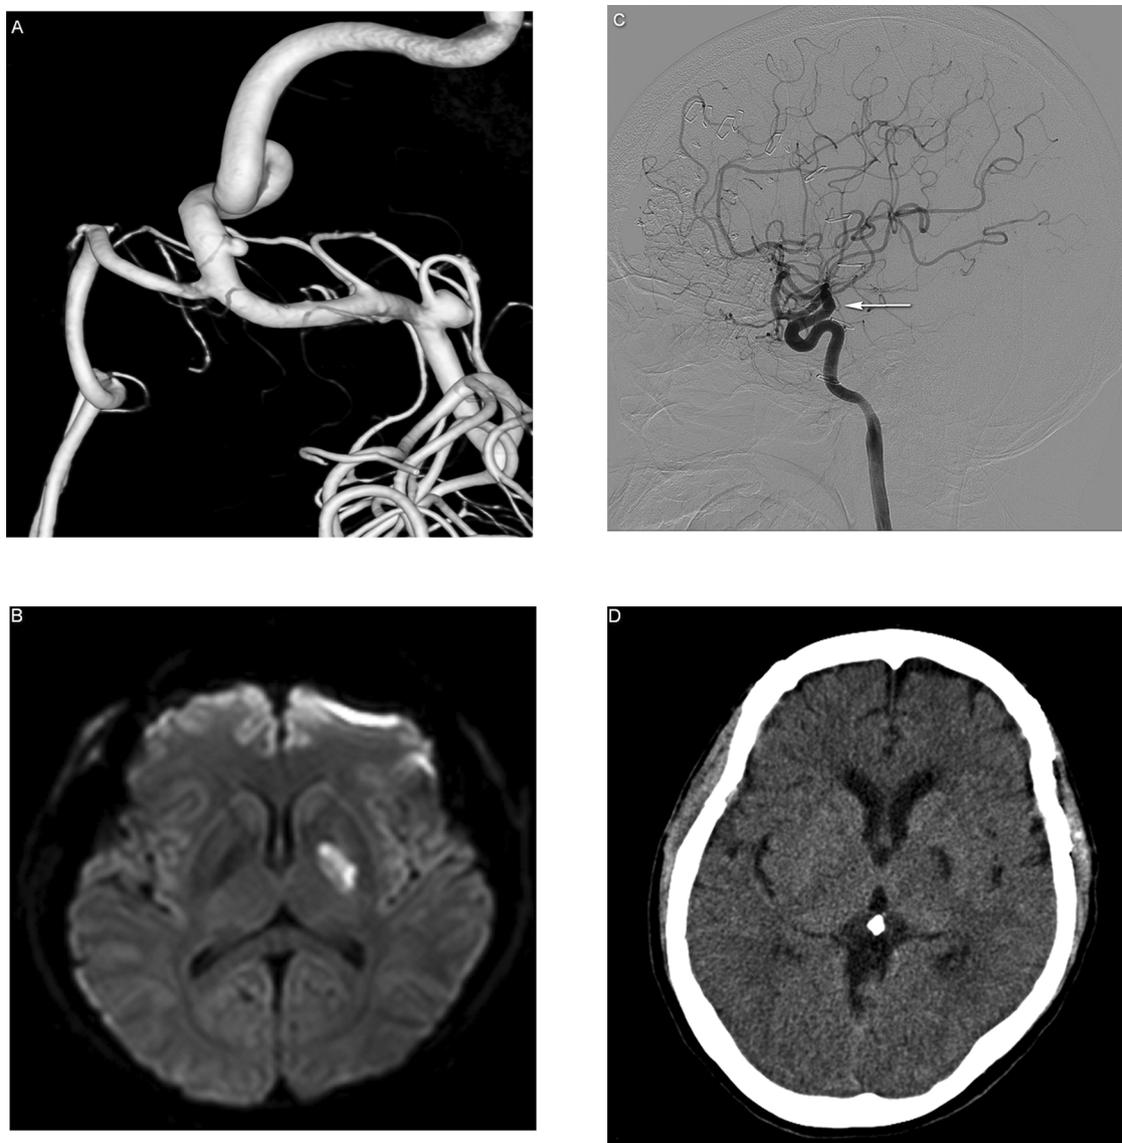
(A) A 54-year-old woman had multiple unruptured intracranial aneurysms including in the left anterior choroidal artery (AChA) (2.4 mm) and both middle cerebral artery bifurcations (MCABs) (5.1 mm, left and 2 mm, right). The left AChA and MCAB aneurysms were clipped simultaneously. Then, the right MCAB aneurysm was clipped via a contralateral approach. No intraoperative evoked potential changes were noticed during the surgery. (B) Immediate postoperative neurologic examination revealed right side motor weakness (grade 4) and blurred vision without ptosis and external ocular movement limitation. Emergent brain magnetic resonance imaging (MRI) with diffusion weight images performed immediately showed a 2 cm sized acute infarction at the territory of the anterior choroidal artery including the left corona radiata, adjacent basal ganglia, and posterior limb of the internal capsule. (C) Subsequently, emergent digital subtraction angiography was performed. The left AChA was not compromised (white arrow). Postoperatively, an intravenous steroid injection and proper hydration was maintained for 3 days and 7 days respectively. (D) A follow-up brain computed tomography was performed 7 days after surgery, which showed an old infarction on the regions confirmed via the previous brain MRI. The patient was discharged 10 days postoperatively with blurred vision and a modified Rankin Scale score (mRS) of 2. The blurred vision improved 1 months after surgery and the mRS score changed to 1.
